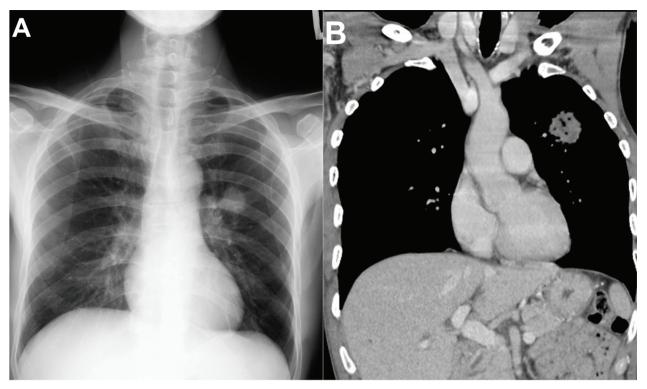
A, Chest radiograph showed a left solitary lung nodule. B, Chest computed tomography showed a left upper lung nodule.
